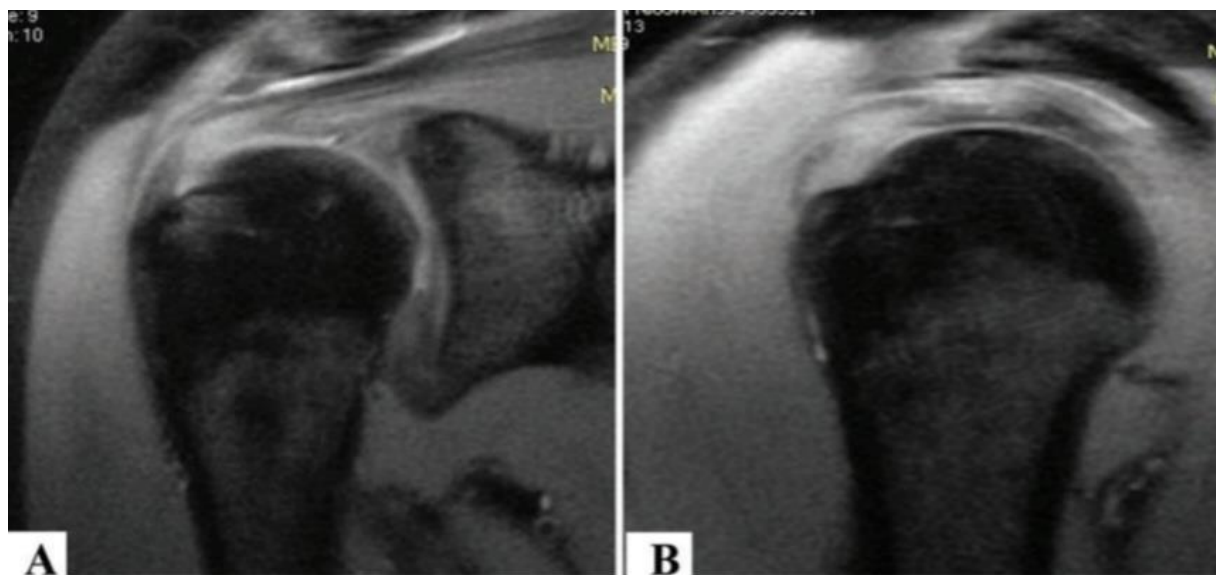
MRI coronal (A) and sagittal (B) images showing partial thickness tear of supraspinatus tendon on the articular surface
